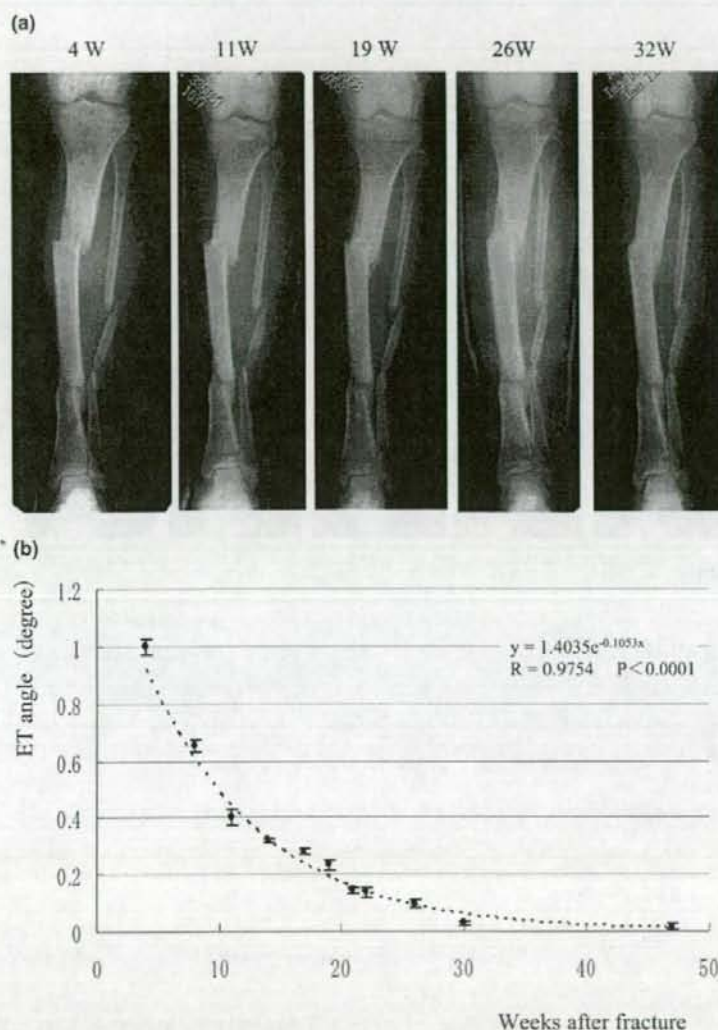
(a) Time sequential change of the fracture site X-ray from 4 weeks to 32 weeks after fracture in case 1 treated with casting. The fracture site healed normally. (b) In the same patient, the ET angle was plotted. The ET angles decreased exponentially over time.
